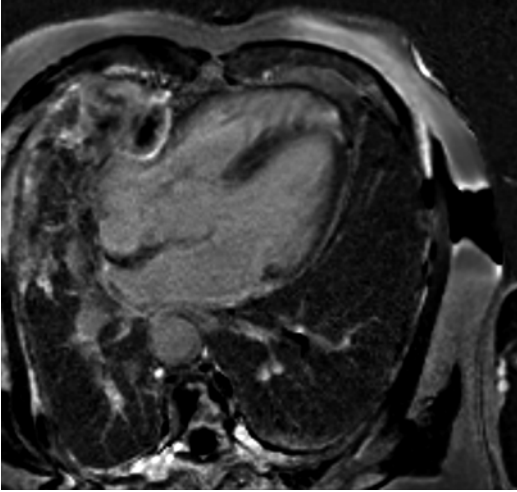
Metastatic disease. MRI delayed enhancement image demonstrating mesothelioma penetrating the pericardium through a pericardial patch (Courtesy of Dr. Michael L. Steigner, Brigham and Women's Hospital, Harvard Medical School, Boston, MA)
